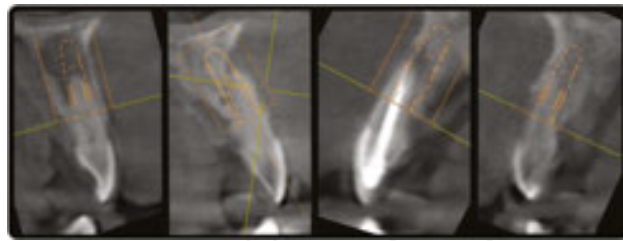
CBCT slices through the teeth show a variety of advanced lesions including almost complete loss of facial bone on three teeth.
